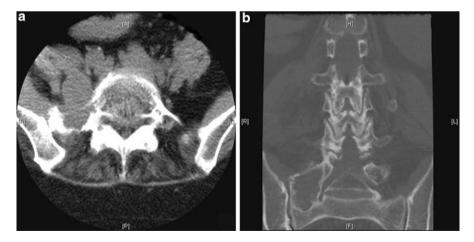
Noncontrast axial (a) and coronal (b) CT images of a malignant peripheral nerve sheath tumor of a right-sided lumbar nerve root developing after sacral irradiation
